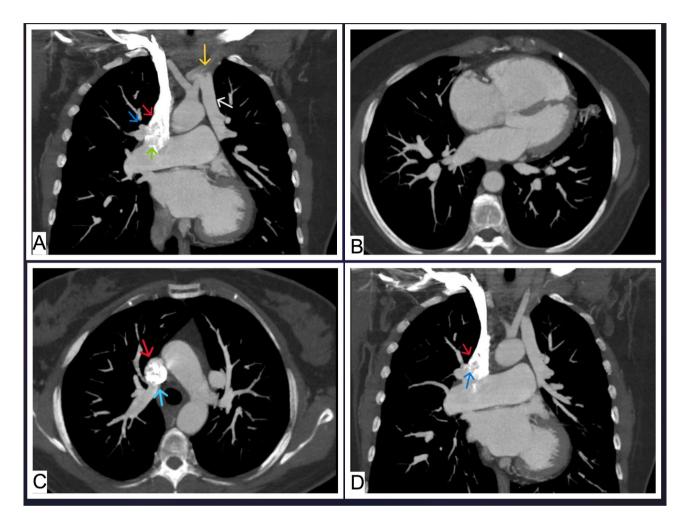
A: The chest computed tomography angiography in the coronal plane reveals abnormal pulmonary vein connections. The vertical vein (white arrow) connects the left pulmonary vein to the left brachiocephalic vein (orange arrow). The right upper pulmonary vein (blue arrow) also connects to the superior vena cava (red arrow). The green arrow highlights the mixture of blood and dye at the site of the connection. B: The axial plane at the ventricular level shows an intact interatrial septum and significant right atrium and ventricle dilation. C: The axial plane at the superior vena cava level reveals an abnormal connection of the right upper pulmonary vein (blue arrow) and the superior vena cava (red arrow). The coronal plane shows an abnormal connection between the right upper pulmonary vein (blue arrow) and the superior vena cava (red arrow)
